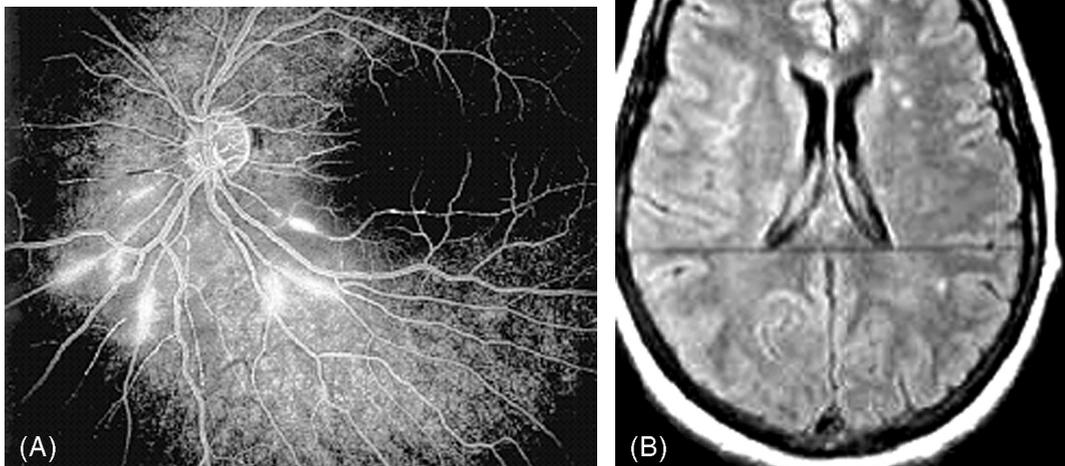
Susac's syndrome. (A) Fluorescein angiography of the left eye of a young woman with bilateral multiple branch retinal artery occlusions related to Susac's syndrome. There are vascular occlusions associated with leakage of the fluorescein. (B) Brain MRI (FLAIR sequence) showing multiple small hypersignals.
